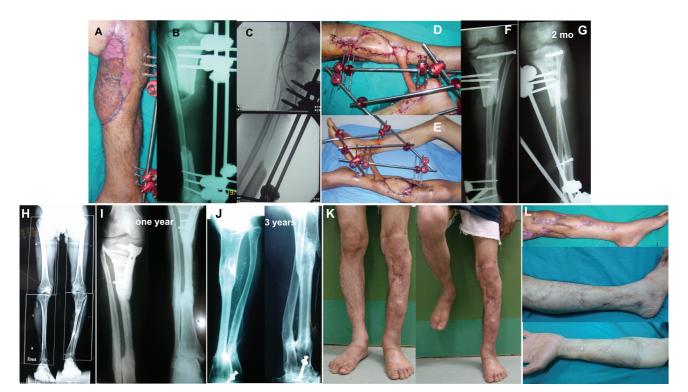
(A) Traumatic left tibial defect with soft tissue loss covered with split-thickness skin graft. (B) Radiographs demonstrating 10-cm midshaft tibial defect. (C) Angiography demonstrating poor distal circulation. (D) A cross-leg vascularized fibular graft was performed. The fibula was inset into the left leg. Vascularization was performed using the posterior tibial artery of the contralateral leg through a radial forearm flap. (E) Two weeks postoperative. (F, G) Immediate postoperative anteroposterior and lateral radiographs. (H) Nine-month postoperative radiographs showing sound healing and varus deformity of the left knee. (I) Lateral wedge closing osteotomy performed at 1 year. (J) Three-year postoperative radiographs demonstrating 90% hypertrophy of the vascularized fibular graft. (K) Clinical standing radiographs. (L) Photographs of the recipient and donor sites.
